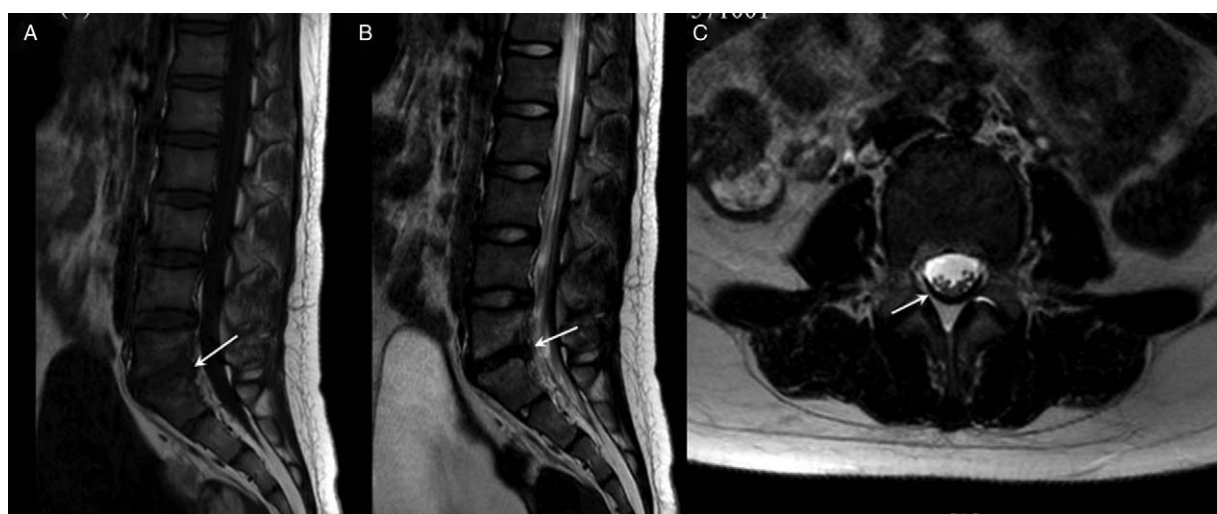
(A and B) Magnetic resonance imaging (MRI) in sagittal view showed that the lumbar physiological curve was straight. Abnormal signals with arrows pointing at the vertebrae edge adjacent to L5 and S1, as well as on the intervertebral discs, the L5/S1 intervertebral space was narrowed. A small depression and eroded bone on the L5 and S1 vertebrae edge was noted. (C) Cross-sectional image showed that a curved soft tissue shadow could be observed on the vertebra posterior border, arrow point at the high T2WI signal, and the anteroposterior spinal canal diameter was 0.5 cm.
